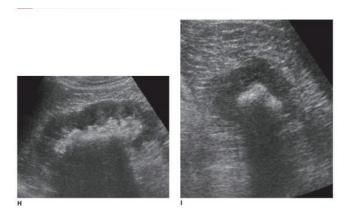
sonographic appearance of stag-horn stone (Diane M, 2012).
